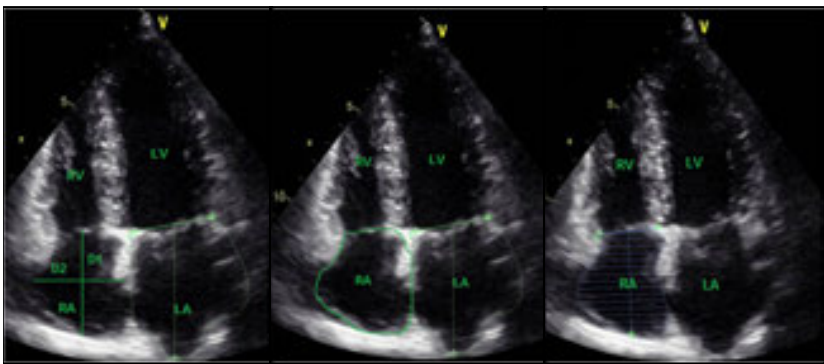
Echocardiography 2D views for right atrium.
